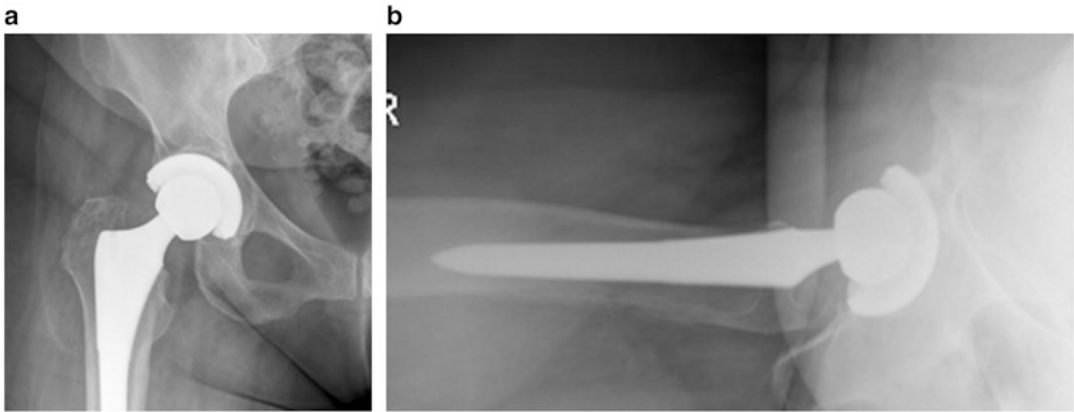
Anteroposterior (a) and cross-table lateral (b) radiographs demonstrating well-fixed acetabular and femoral components with reduced acetabular component anteversion and 13 mm of anterior component overhang
